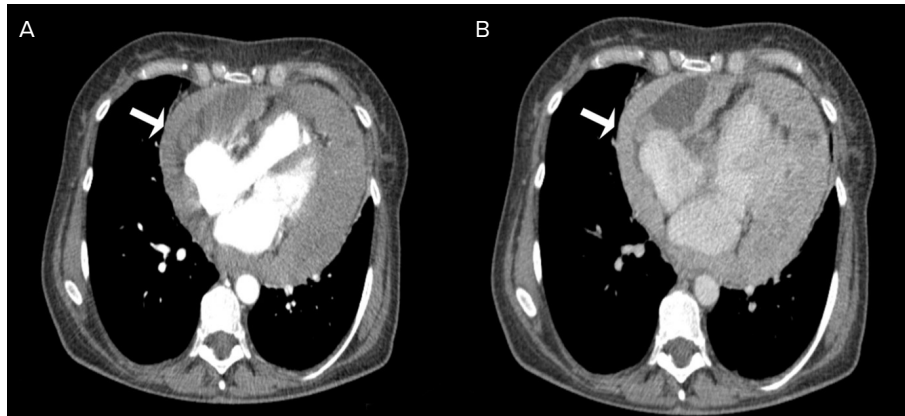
Contrast CT scan, first presentation: arterial phase (A) and venous phase (B). White arrows indicate circumferential pericardial thickening with both fluid and semi-solid components.
